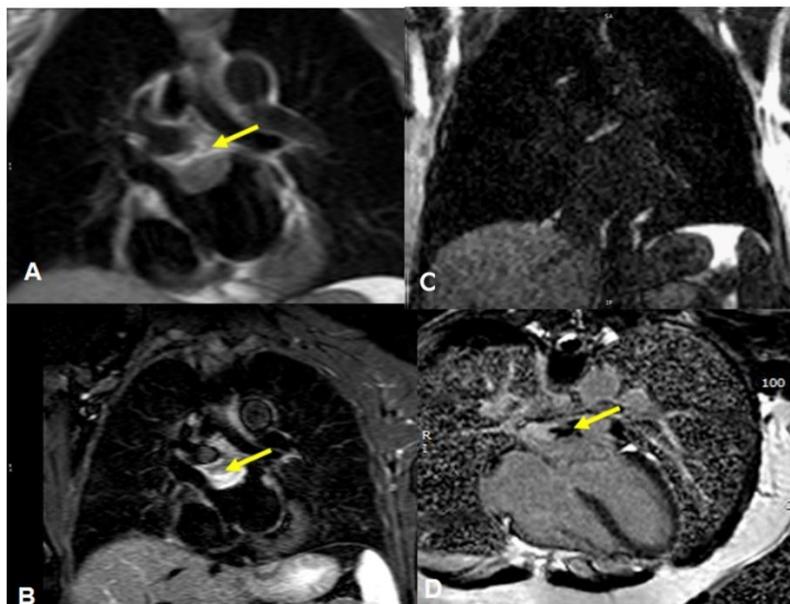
CMR study. LA mass (yellow arrows). A) T1-weighted sequence depicting an isointense posterior left atrium wall mass. B) corresponding T2-weighted sequence with fat-suppression showing high signal intensity across the mass. C) first-pass perfusion with contrast uptake. D) delayed enhancement sequence with a heterogeneous aspect positive for the presence of fibrosis.
